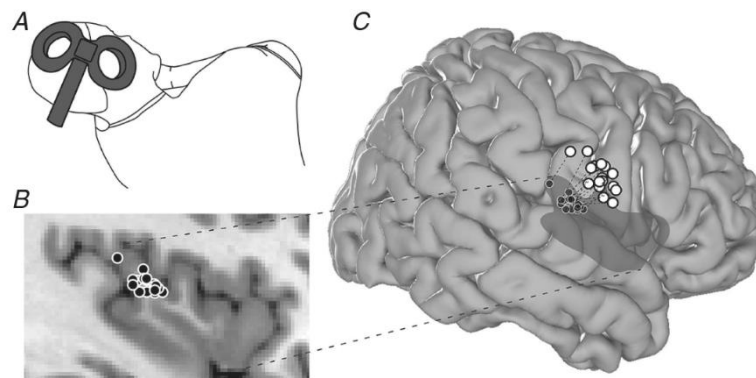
Localization of the target sites in the dorso-posterior insular cortex and the localization of the positions of the TMS coil. A, position of the TMS double cone coil with the handle pointing backwards during the cTBS protocol; the participants were lying in left lateral decubitus position. B, localization of the target sites in the dorso-posterior insular cortex (black circles; MNI coordinates x: [34 to 42], y: [-17 to -5], z: [4 to 14]) defined on individual 3D structural MRI image for the MRI-guided neuronavigation system. C, projections on the cortical surface of the position of the center of the TMS coil (white circles) at which cTBS was applied for all participants; the corresponding target markers in the dorsal posterior insula are indicated by the black circles; the location of the insula is indicated in dark grey. The apparent discrepancy between the target markers and the position of the coil is due to the 2D visualization of the different orientations of the TMS coil according to the individual curvature of the head (MNI Colin 27 brain reconstruction adapted from JuBrain; Mohlberg et al. (2012)).
